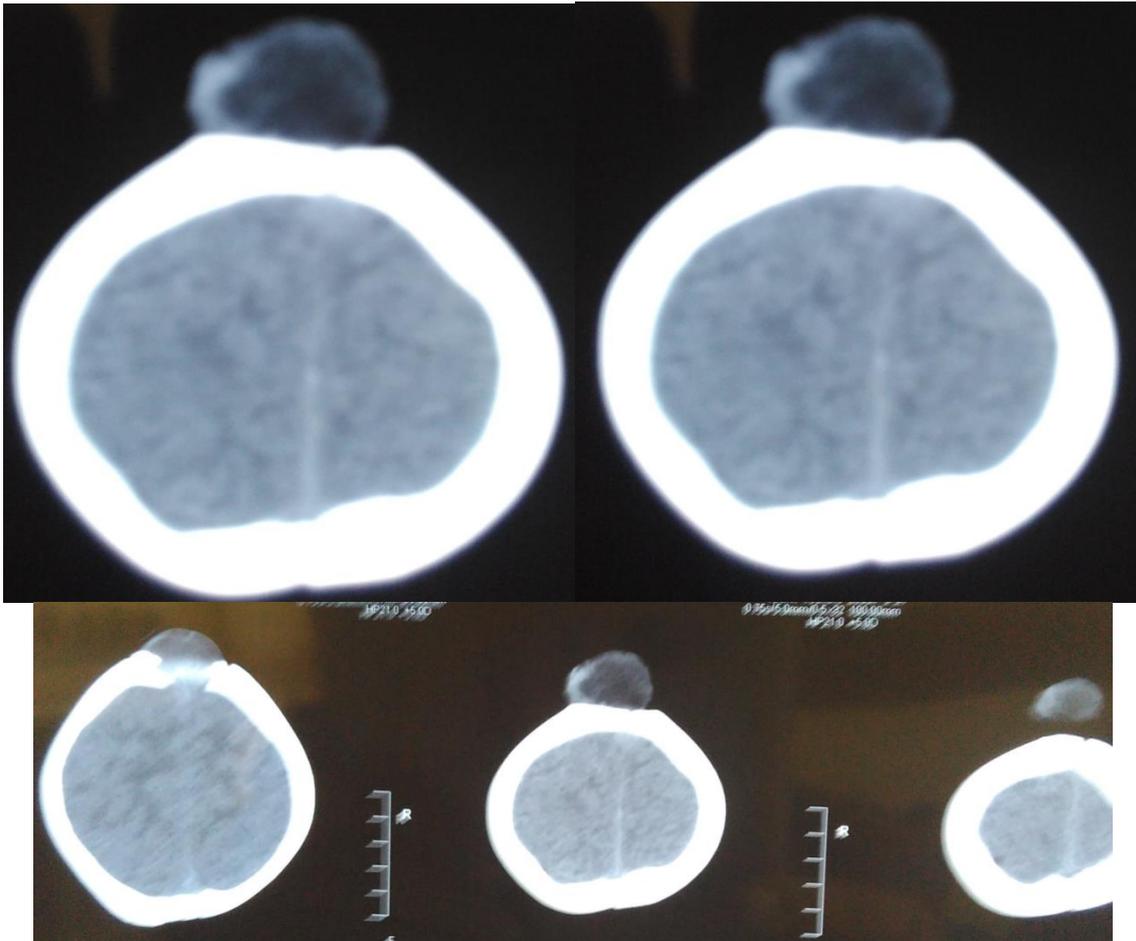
Case 1 Post contrast CT scan showed connection of the lesion to superior sagittal sinus.
